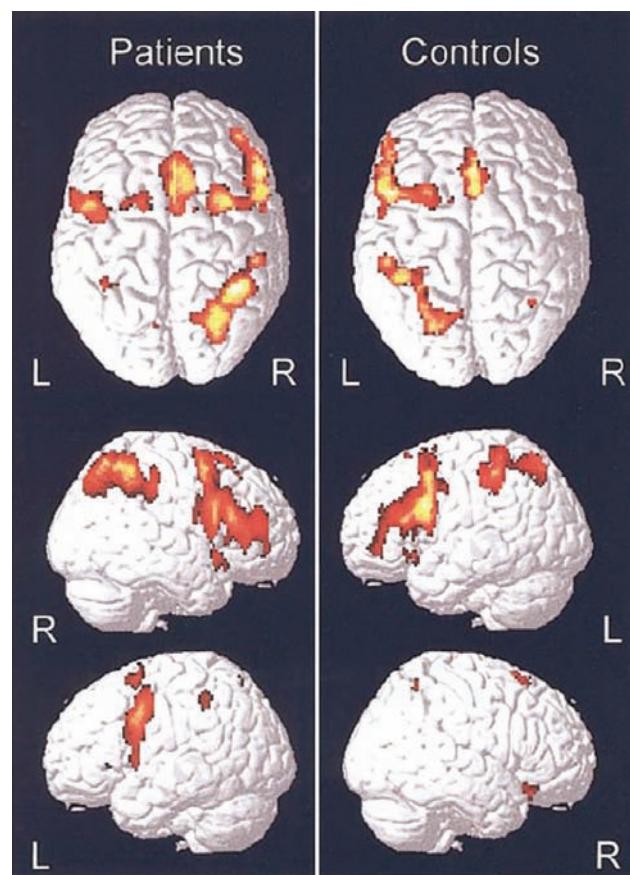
Organization of language on the right side in children following early left-side brain lesions. Functional MRI study by Staudt et al. (30) demonstrated normal expected language organization on the left side. However, in patients with left-brain lesions early on in life, language function was predominantly right side. Abbreviation: MRI, magnetic resonance imaging. Source: From Ref. 30 with permission from Elsevier.
